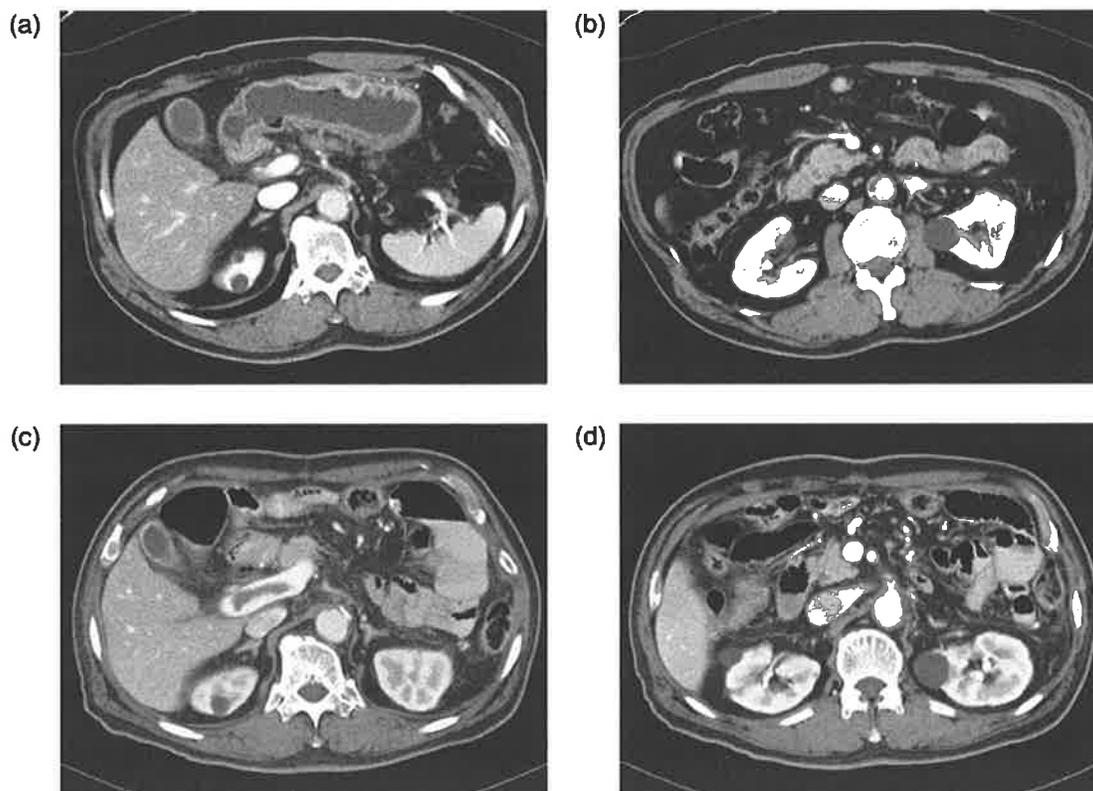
Transverse CT images acquired with ATCM (a, b) and FTC technique (c, d) in a 66-year-old man (BMI 29.09 kg/m^2 , 69 kg). Objective image noise for ATCM and FTC were 12.03 and 13.5, respectively, and all qualitative image scores were more than 3 in two readers. Radiation dose reduction of 57.6% was noted with the combined ATCM
